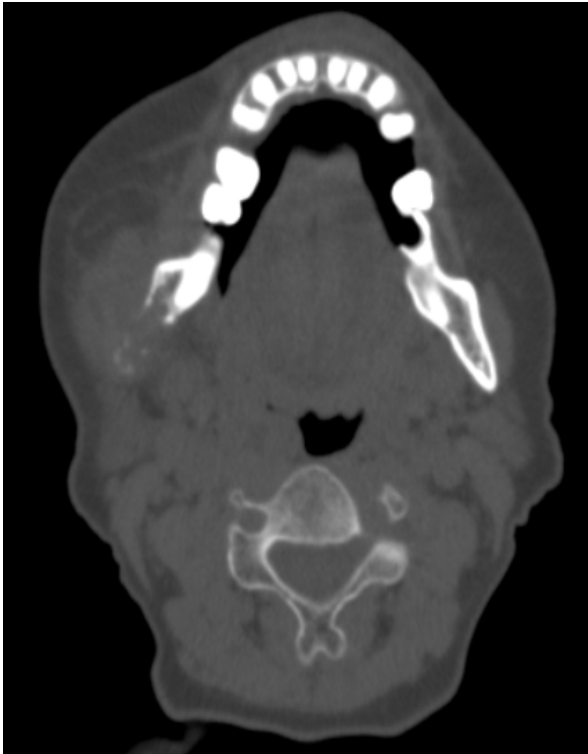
CT axial image-Bone window
